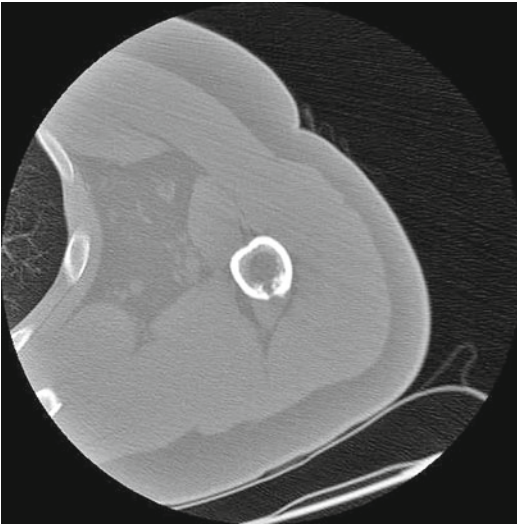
Pre-interventional CT of a bone metastasis of the humerus from a cholangiocellular carcinoma (same patient as in Fig. 13.67). Free access from the posterior aspect without nerves or vessels within the expected ultrasound beam path
